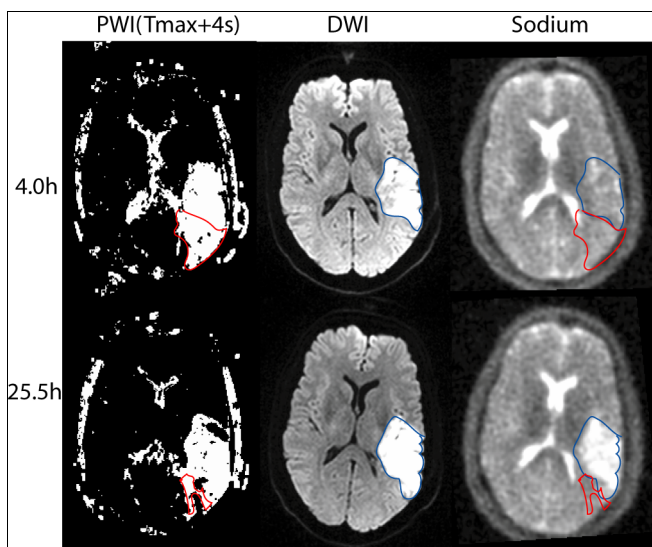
Images of a 46 year old male stroke patient (P1) demonstrating elevation in relative sodium intensity in the DWI lesion core (blue outline) in the subacute time but no change in the penumbral region (red outline).
